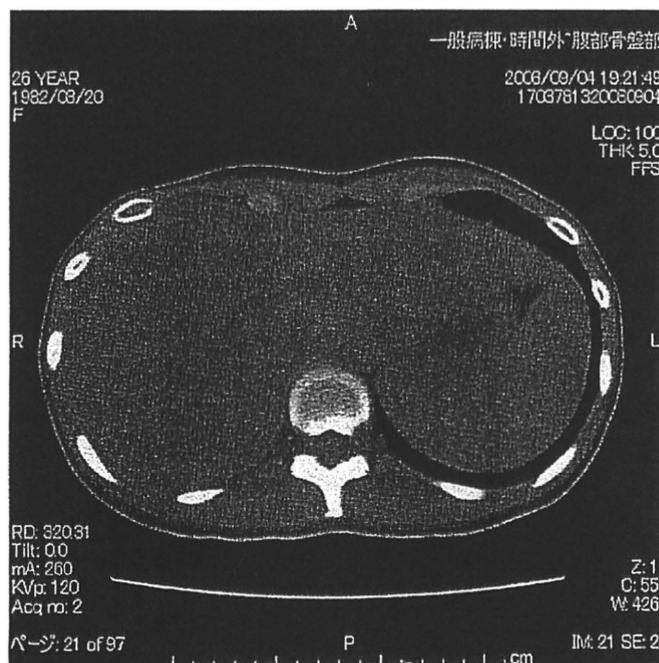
Hepatomegaly in a patient with phenytoin-induced hypersensitivity syndrome showed by CT.
